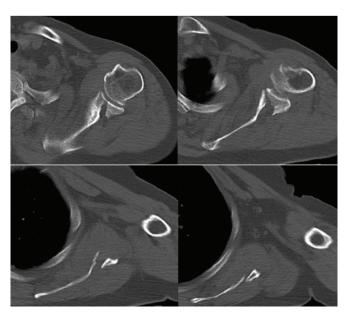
Joint CT horizontal section: Displaced glenoid fracture scapula extends to medial edge.
